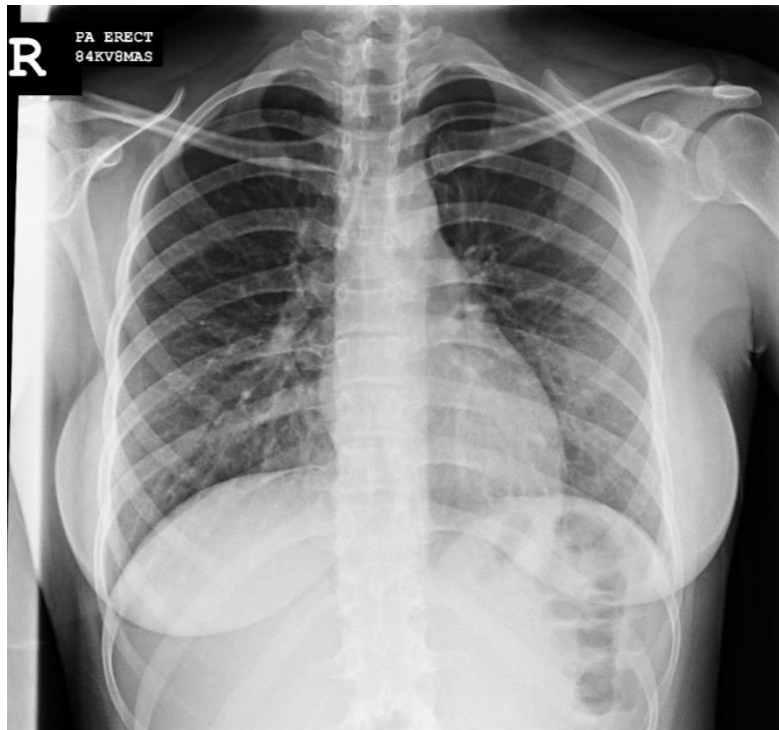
Plain chest radiograph showing mild haziness at the left lower zone suggestive of early pneumonitis.
